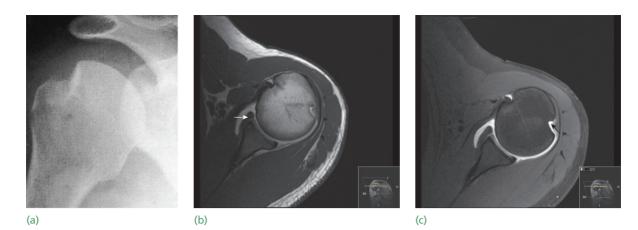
Anterior instability – imaging (a) The plain X-ray shows a large depression in the posteriosuperior part of the humeral head (the Hill–Sachs sign). (b,c) MRI shows both a Bankart lesion, with a flake of bone detached from the anterior edge of the glenoid, and the Hill–Sachs lesion (arrows).
